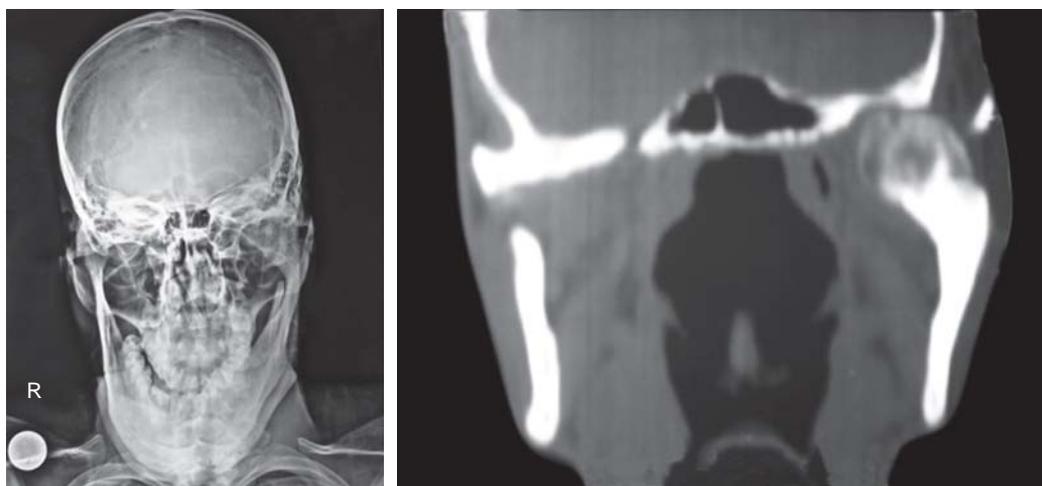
Posteroanterior (PA) view and computed tomography scans showing condylar enlargement on left side
